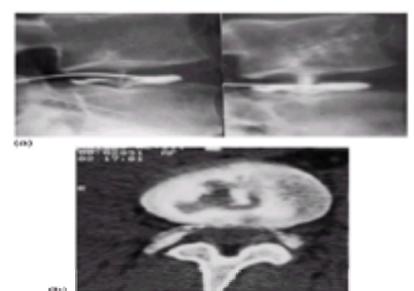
End-plate fracture. (a) Discography. The initial radiograph shows a spurt of contrast going upwards from the nucleus into the end-plate of the overlying vertebral body. Subsequently, the defect is shown to be much larger, but patient movement occurred because of pain during injection. (b) CT scan showing contrast leaving the nucleus and entering the undersurface of the bone.
